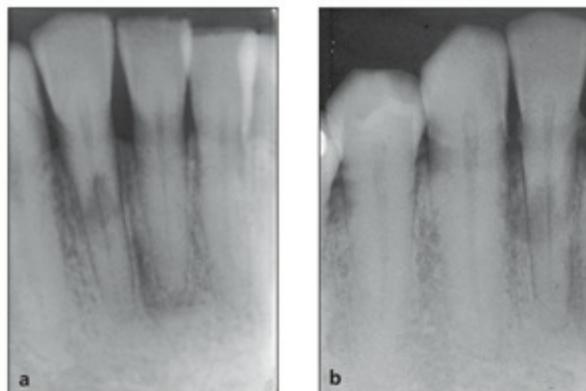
(*a and b*) External resorption. Radiographs from two different horizontal projections depict movement of the lesion to outside the confines of the root canal.
